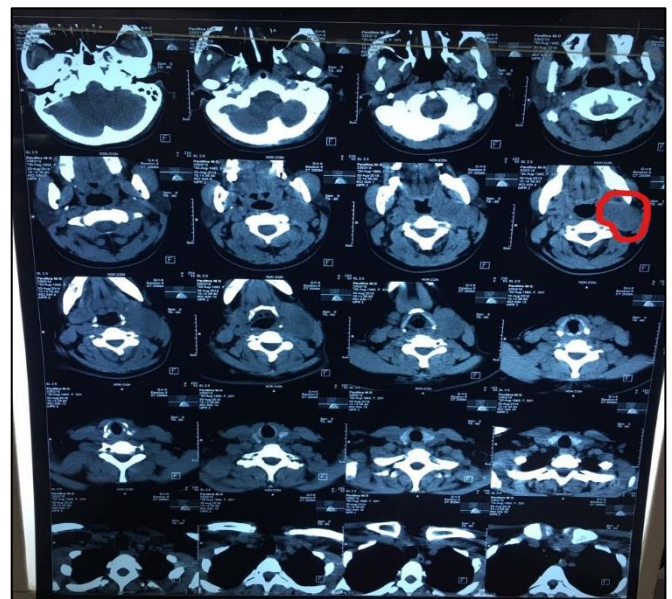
CT scan of the lesion.
